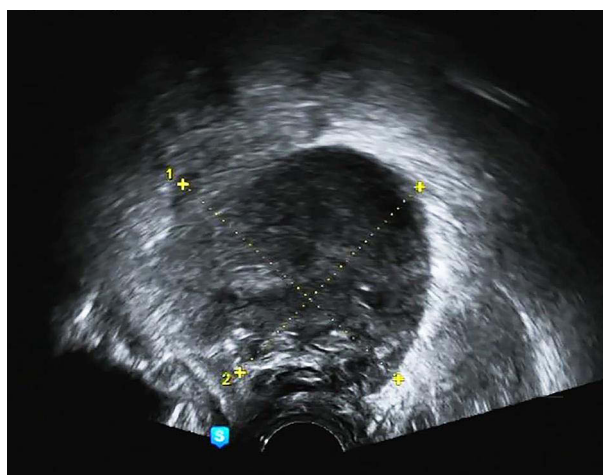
Grayscale ultrasound image showing a cystic solid mass with clear boundaries in the posterior vaginal wall by abdominal ultrasonography (2020.05.23, (A)) and vaginal ultrasonography (2020.05.23, (B)).
